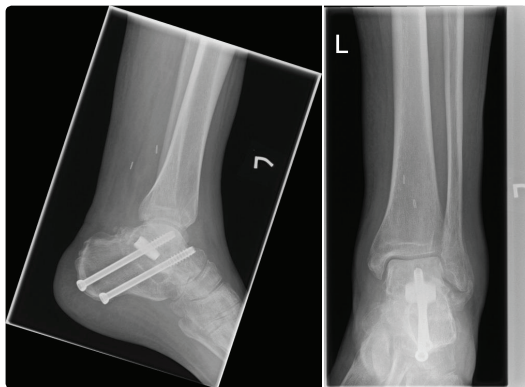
Radiographs taken 6 months after surgery showing revascularization of talus and incorporation of subtalar fusion.
